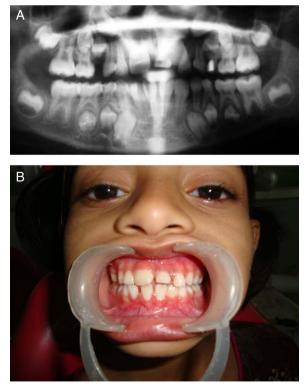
(A) Orthopantomograph of patient's younger sister showing congenitally missing 12 and 22. (B) Photograph of patient's younger sister.
